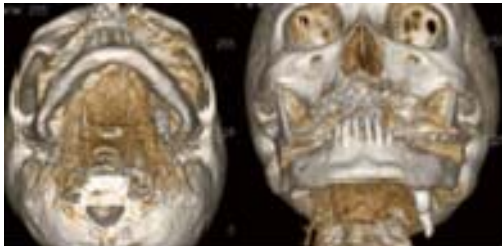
3D-CT showing a large club-shaped bone-like mass in the left submandibular region.
